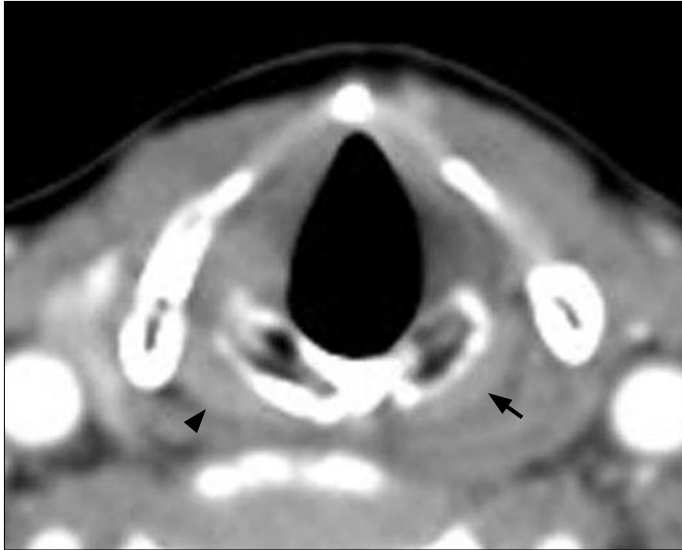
Axial CT image at the cricoid level demonstrates mild atrophy of the left posterior cricoarytenoid muscle (arrow) compared with the normal right side (arrowhead).
